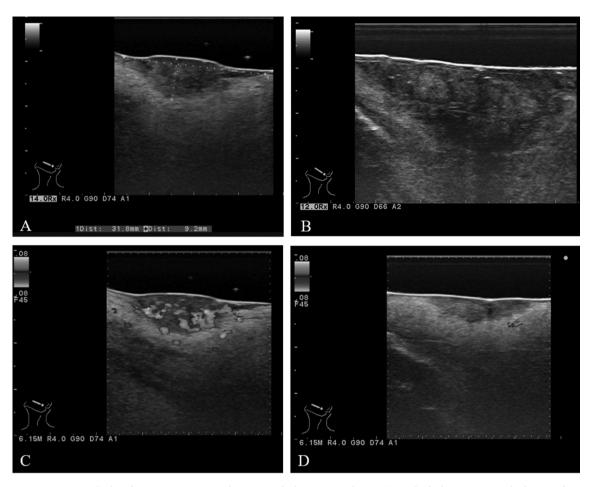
Measurement method and assessment criteria for intraoral ultrasonography (IUS). Methods for measuring the longest diameter and thickness (A); a representative case showing internal echo intensity (B), high internal and peripheral vascularity (C), and low internal and peripheral vascularity (D). Internal echo intensity is the hyperechoic area in the lesion (B). Abundant signs of high internal and peripheral vascularity on Doppler ultrasound image (C).
